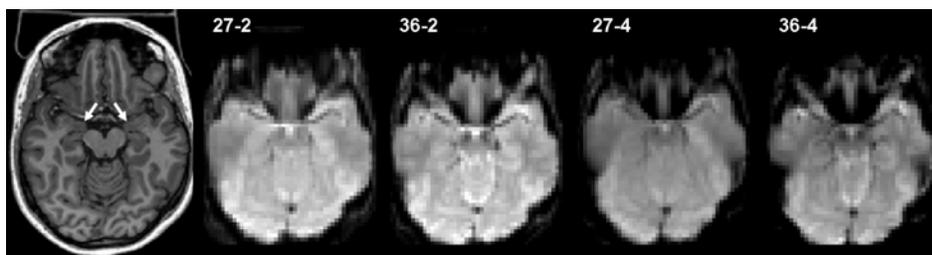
Anatomical MRI of a single subject showing the bilateral amygdala region (left, arrows). Corresponding EPI raw images reveal the different degrees of susceptibility artefacts in respective sequence versions.
